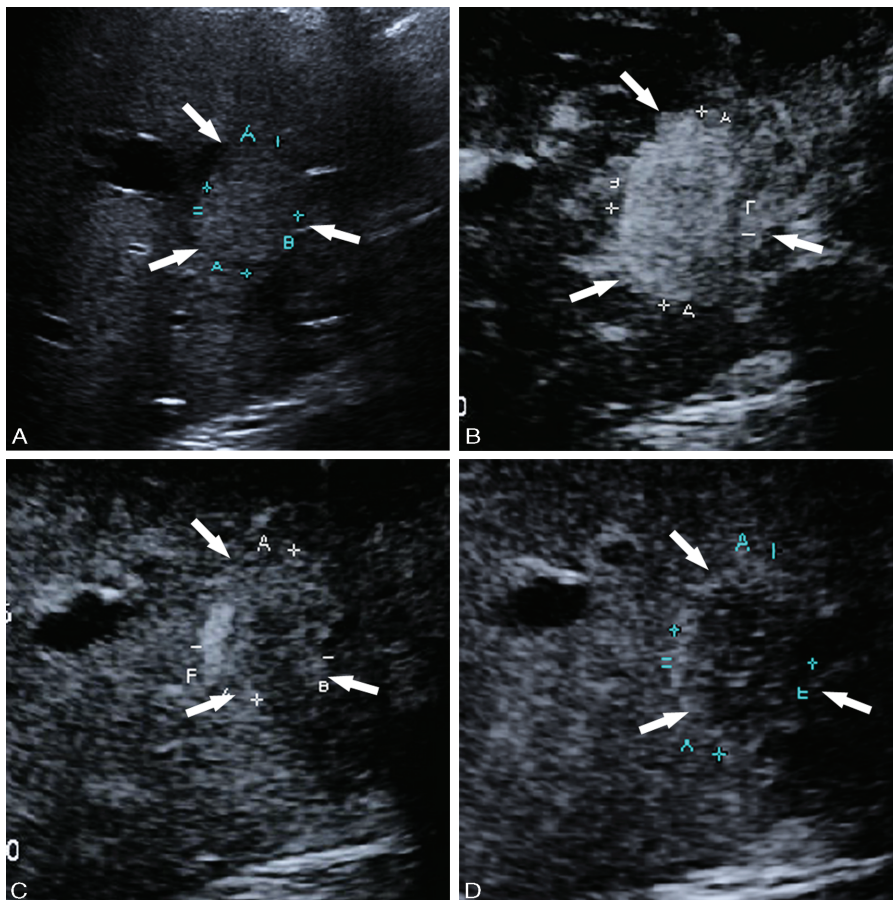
Primary hepatic neuroendocrine tumor in a 58-year-old woman (case 5). A, Conventional B-mode ultrasonography revealed an isoechoic lesion (arrow) 4.8 cm in diameter. B–D, Contrast-enhanced ultrasonography obtained at 18 s (B), 43 s (C), and 168 s (D) showed homogeneous hyperenhancement in the arterial phase (B), hyperenhancement in the periphery and hypoenhancement in the central in the portal venous phase (C), and hypoenhancement in the late phase (D).
